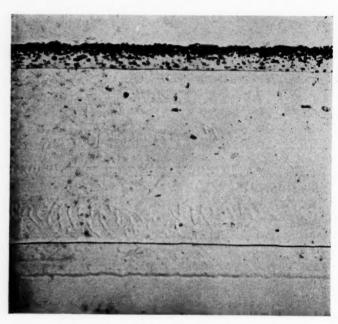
Cross-section of film exposed to X-rays by medium of intensifying screen, having same density as shown in Figure 1.
